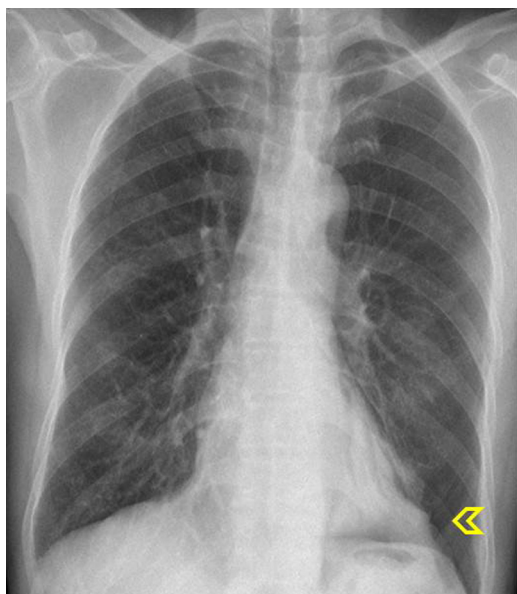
A chest X-ray demonstrating pneumothorax (arrow head) in the left hemithorax.
